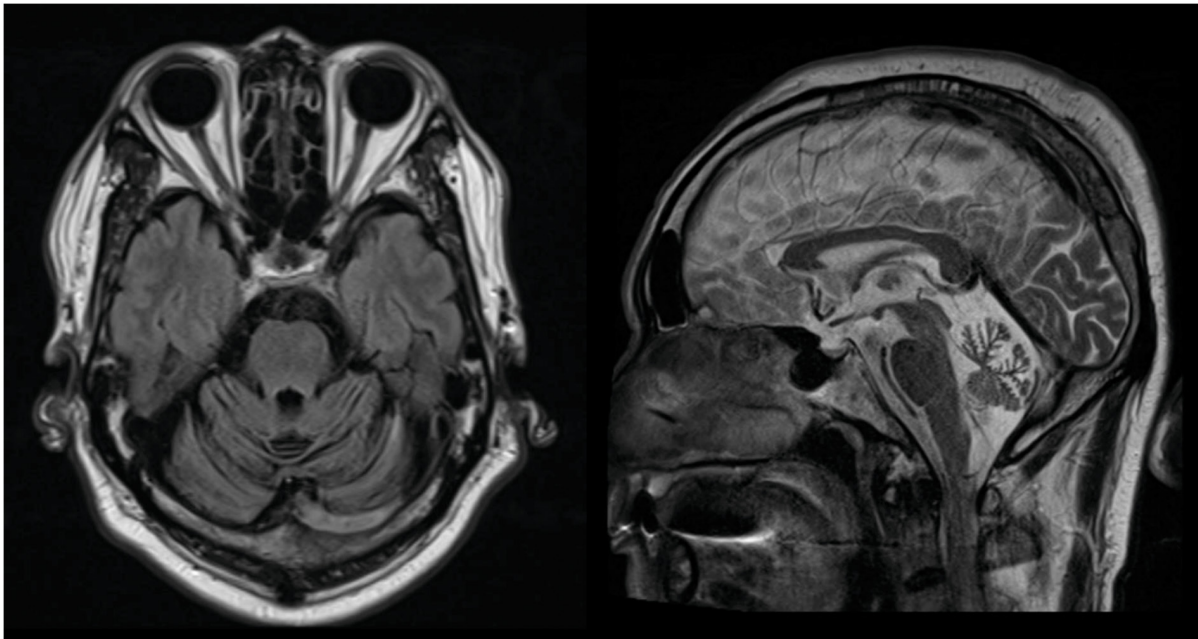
Brain MRI of the proband revealed severe diffuse cerebellar atrophy.
